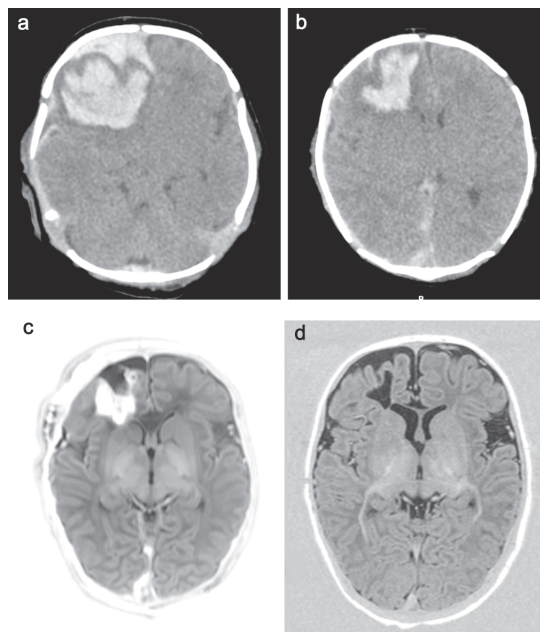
CT performed on day 2 (a, b), showing a large intraparenchymal and SDH in the right frontal lobe, causing a shift in midline. MRI and IR axial view obtained on day 8 following craniotomy (c) showing resolution of the midline shift and reduction of subdural and intraparenchymal hematoma. A repeat MRI, IR axial view at 3 months (d) shows a small area of cavitation and mild atrophy of the right frontal lobe. Outcome was well within the normal range at 2 years of age.
